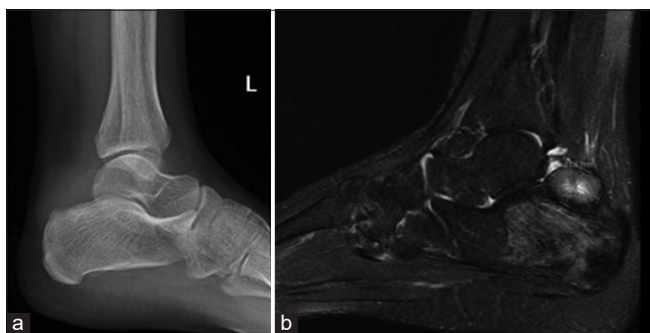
(a) Pre-operative radiograph lateral view and (b) magnetic resonance imaging post contrast sagittal section showing involvement of calcaneus with posterior soft-tissue component of tumor.
